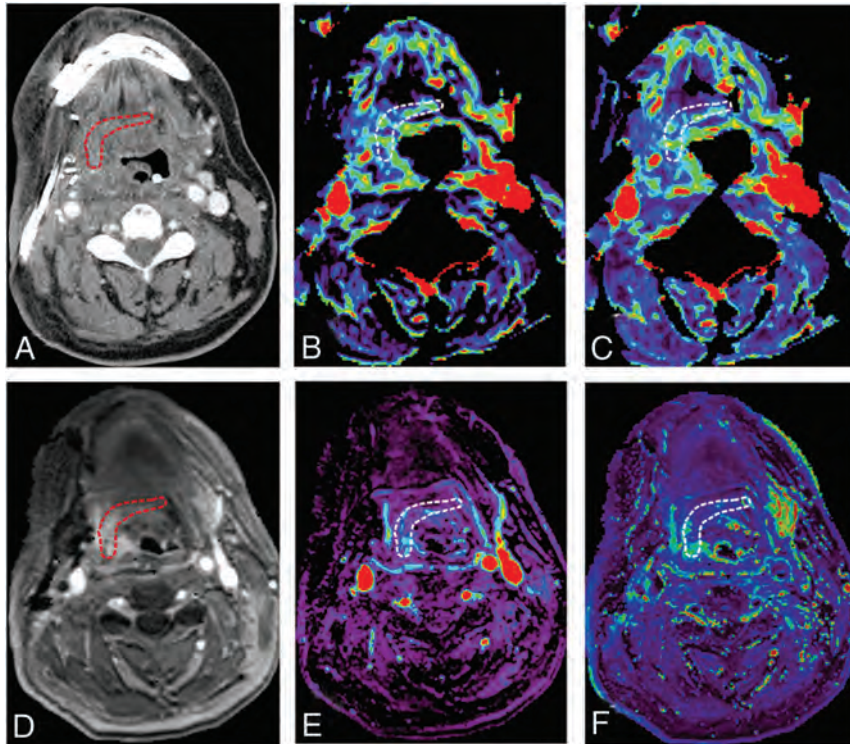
A 49-year-old male with tonsillar squamous cell carcinoma was treated with glossectomy, mandibulotomy, and neck dissection. An anterolateral thigh free flap was utilized for treatment of the soft tissue defect. No wound failure was observed. DCE-MR imaging and CT perfusion were performed 3 days after the surgery. A, An ROI is placed within the junctional area of the free flap on contrast enhanced CT. B, Blood volume (mL/100 ml) and C, blood flow (mL/100 ml/min) are calculated and are 7.67 mL/100 ml, 29.7 mL/100 ml/min, respectively. D, An ROI is placed on the permeability map within the junctional area of the free flap and DCE-MR imaging parameters are calculated. E, Vp and F, K^{trans} (minute⁻¹) are 0.17 and 0.19 (minute⁻¹), respectively. Red and white circled areas represent region of interests.
